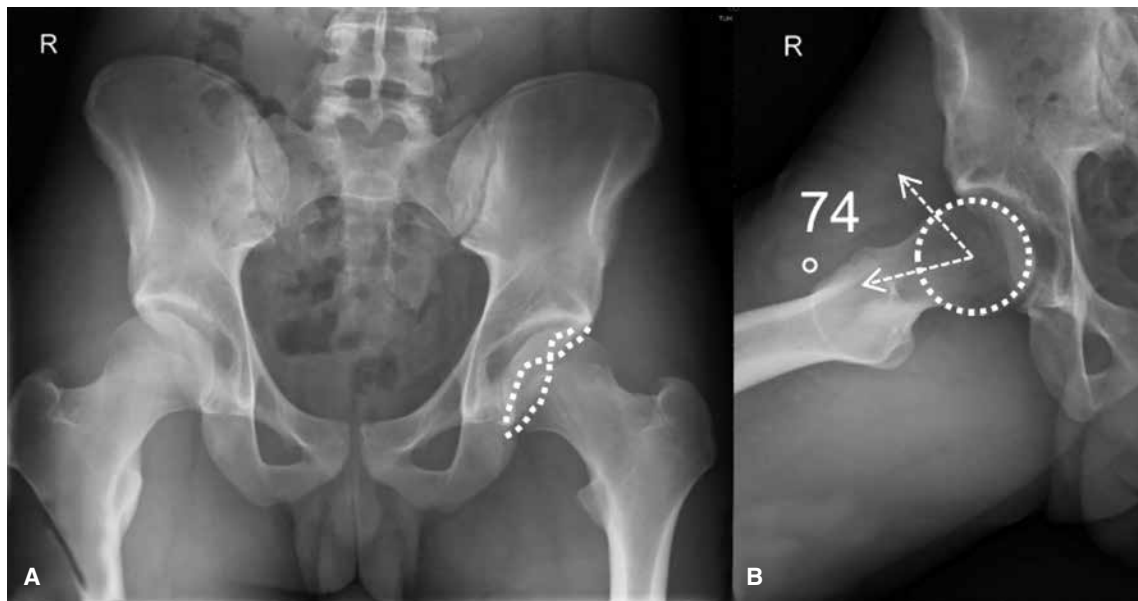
(A) Supine AP pelvis radiograph of a 19-year-old male patient with cranial crossover, apparent cam morphology, and an alpha angle measured at 74 degrees, demonstrating that the alpha angle can be used as an indication of FAI. (B) Lateral Dunn radiographs confirming cam morphology and asphericity of the femoral head.
